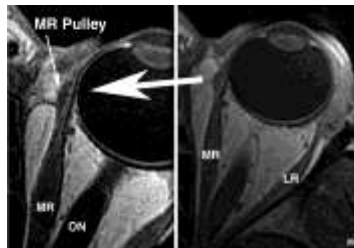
Examples of magnetic resonance image (MRI) of a human left orbit in 2 mm thickness planes at 390 micron resolution at right, and 312 micron resolution at left.
